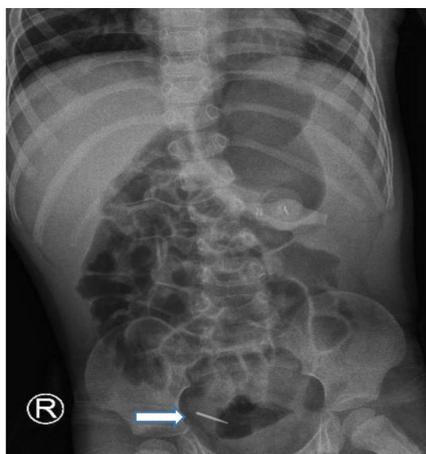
X-ray after 6 hours showed foreign body in the distal small bowel.
